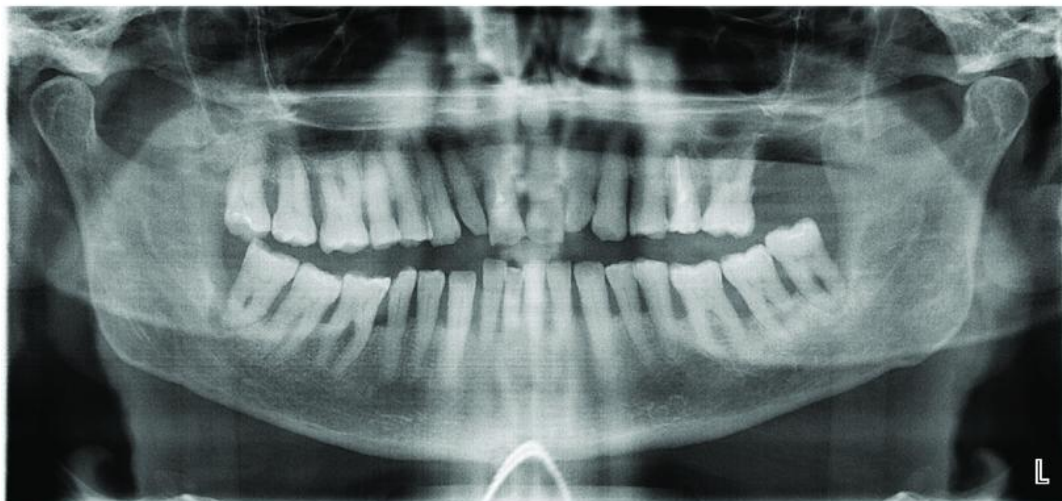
X-ray findings of melanin hyperpigmentation
